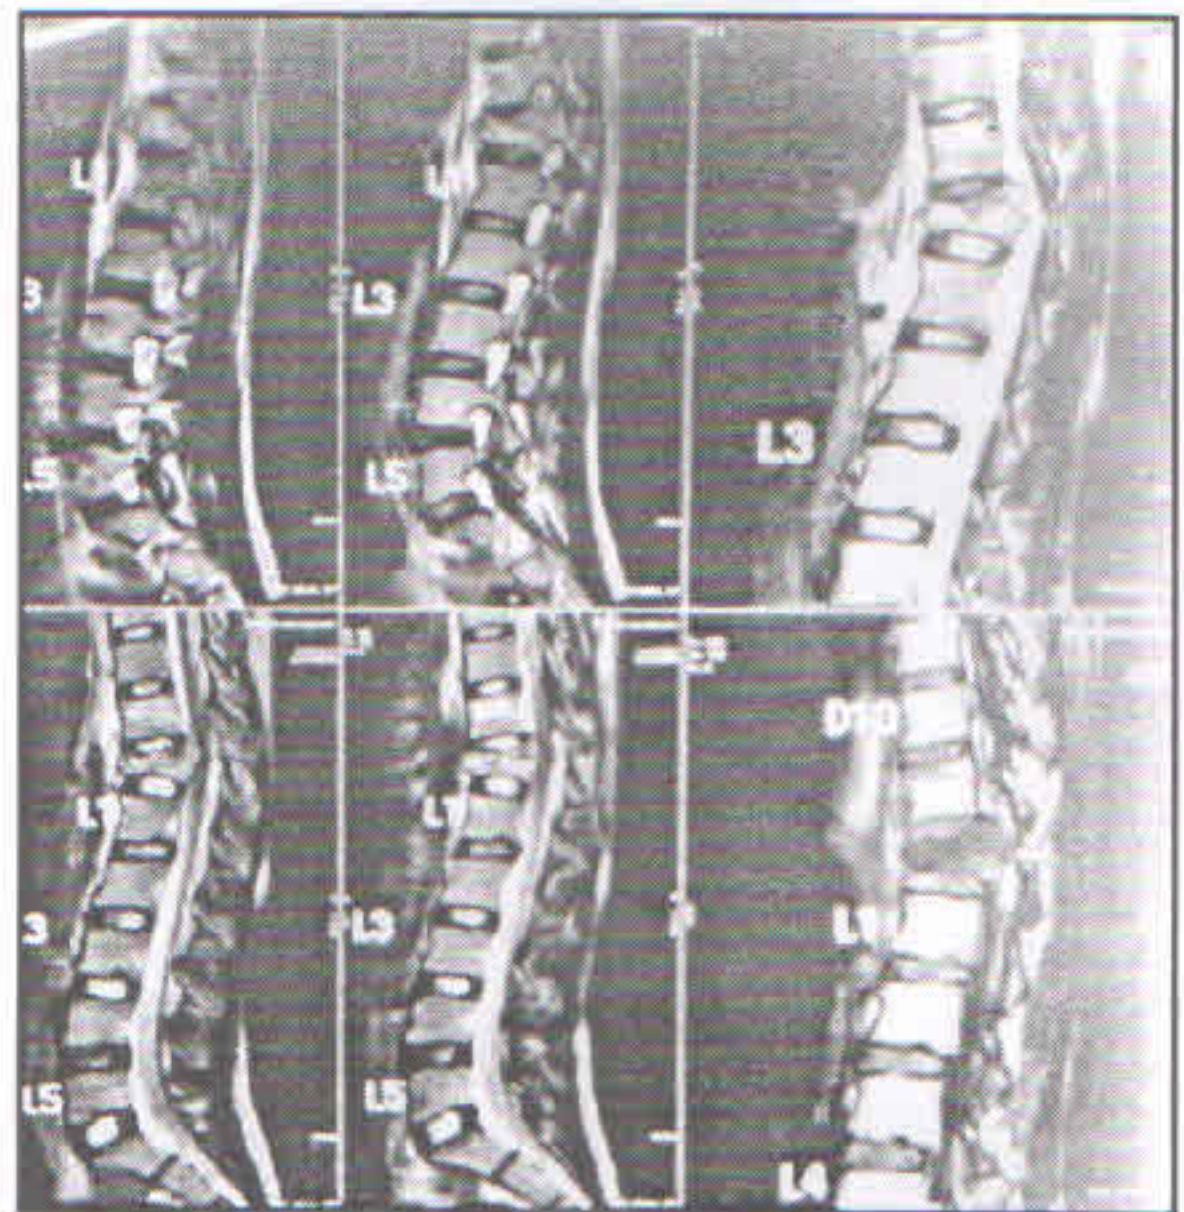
(a) : # D12, 25 Yr/M, Pre operative grading A, P5 1 (b) MRI of same patient
